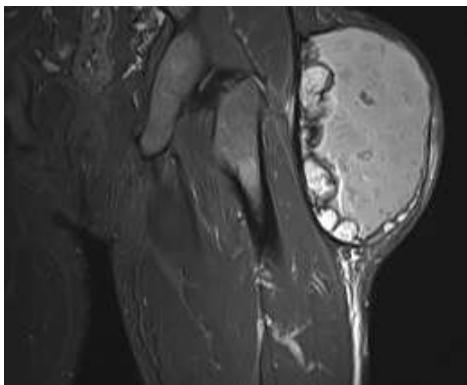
MRI image of the lesion
